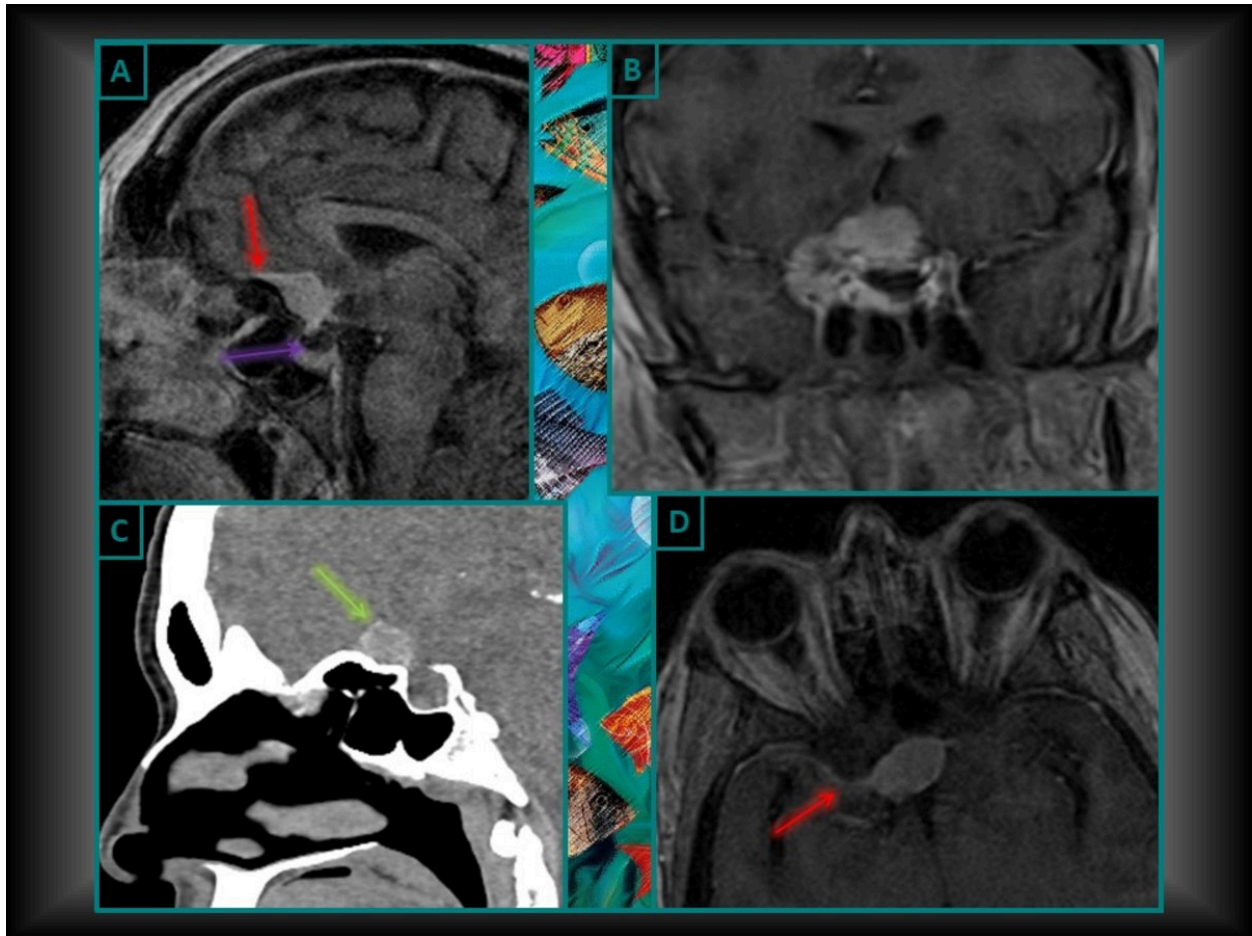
SUPRASELLAR MENINGIOMA Sagittal post-contrast T1-W (A), Coronal post-contrast T1-W (B) and Axial post-contrast T1-W (D) showing an intensely enhancing homogenous mass in suprasellar location with separately visualized pituitary gland (violet arrow). Sagittal CT Scan (C) reveals a spontaneously hyperdense image in suprasellar location . The red arrow indicates the spread of the lesion along the meninges, dural tail sign.
